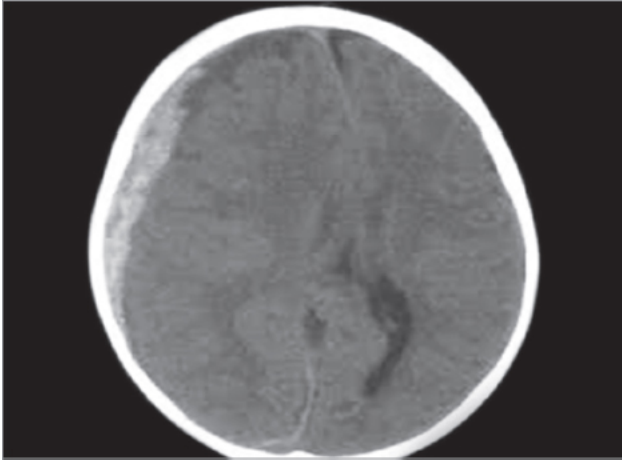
Plain CT head showing hyperdense shadow which is concavo-convex in appearance suggestive of acute right subdural hematoma.
